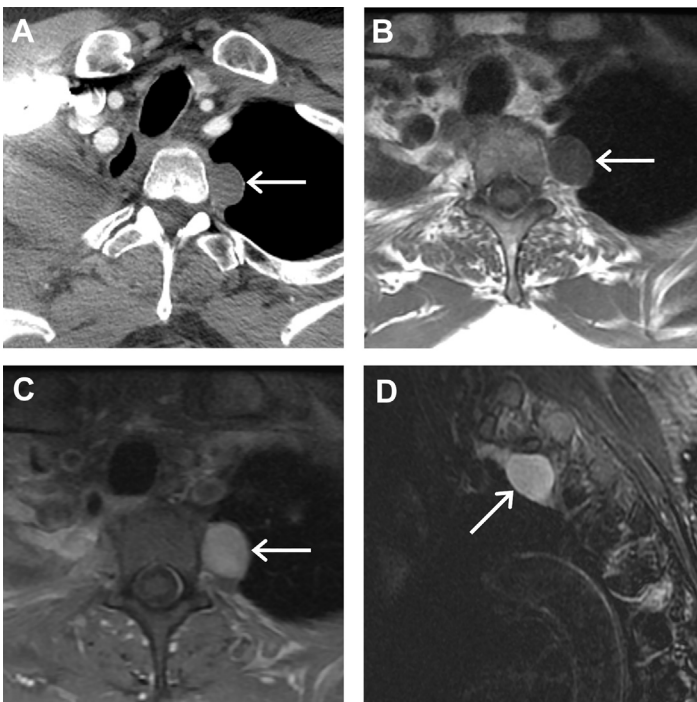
Schwannoma. (A) Contrast-enhanced axial CT of the chest of a 56-year-old woman with a history of lung cancer shows a well-circumscribed low-attenuation lesion in the left paravertebral mediastinum (arrow). Axial T1-weighted (B) and postcontrast T1-weighted MR images (C) and sagittal T2-weighted MR image (D) demonstrate homogeneous enhancement and high T2 signal intensity (arrows). Biopsy revealed schwannoma.
